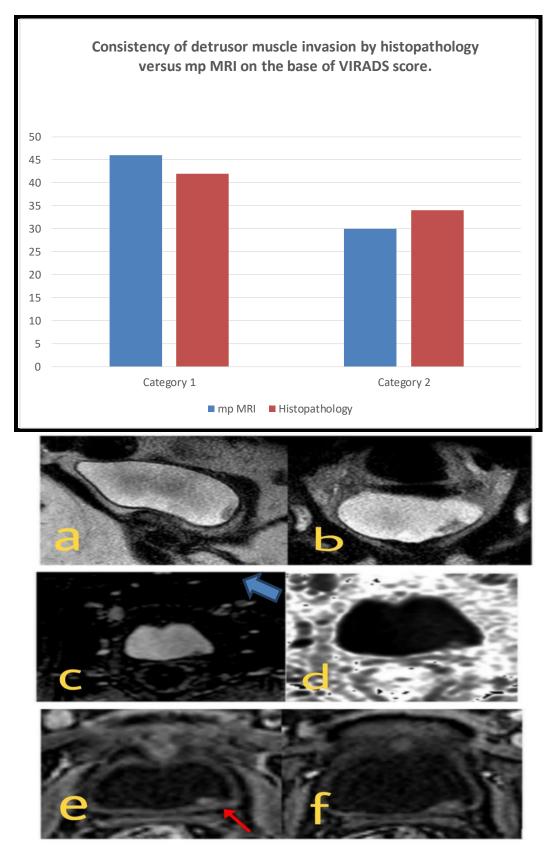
A 50-year-old female patient complaining of dysuria. Sagittal (a) and coronal (b) T2WI images show a mass with no sort of muscle invasion seen at left posterolateral UB wall within bladder trigone peripherally, seen polypoidal in shape seen not interrupting the underlying detrusor muscle of low signal intensity, without perivesical fat extension. DWI (c)
